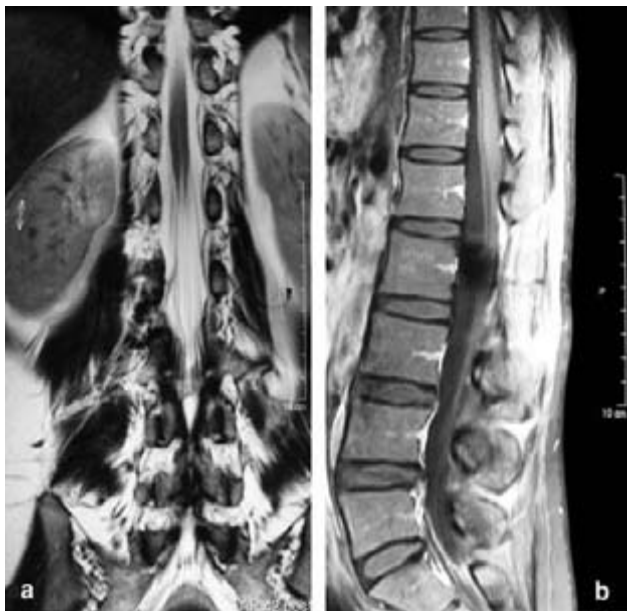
Postoperative coronal (a) T2- weighted image (TR 2700, TE 150) and sagittal Gd-DTPA enhanced (b) T1-weighted MR-images (TR 540; TE 12) confirmed a complete tumour resection 24 months after surgery.
